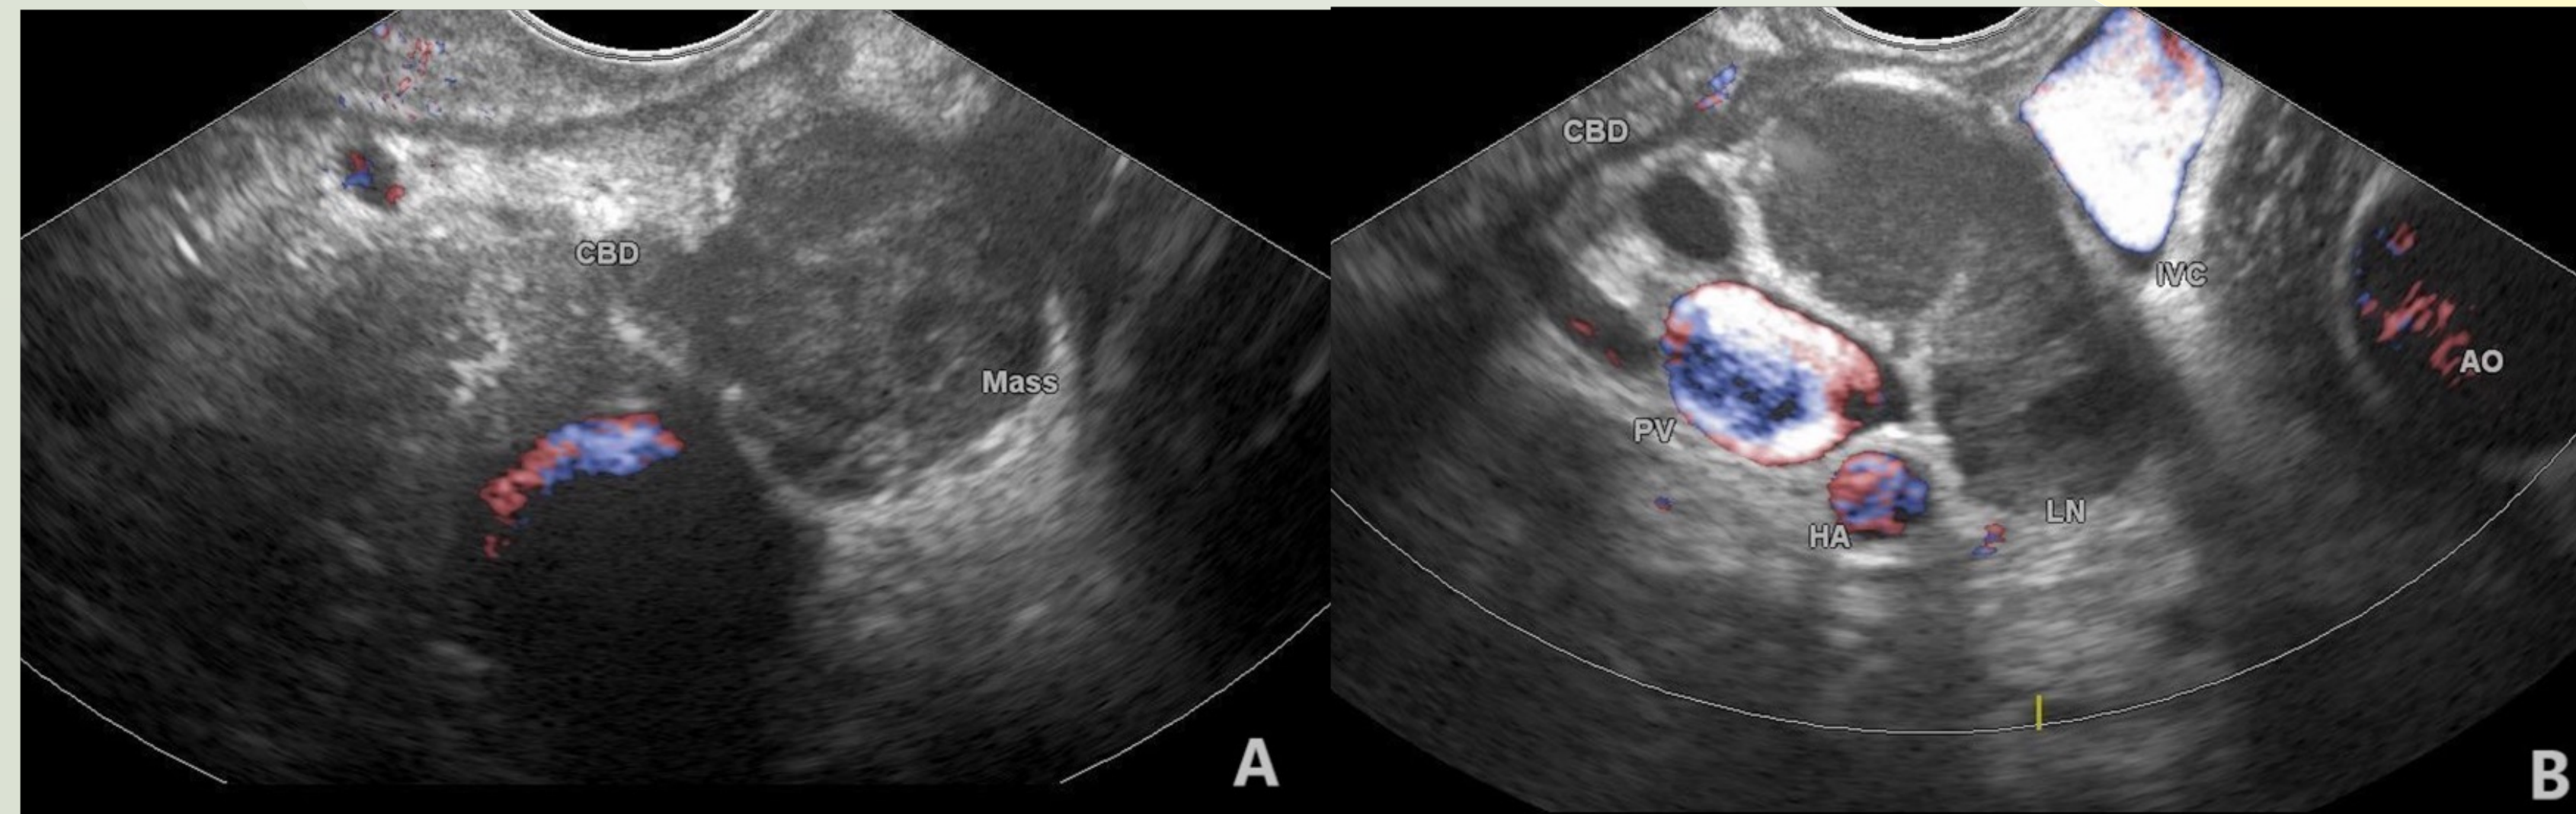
A,B: endoscopic ultrasound images showing the tuberculous lymphadenopathy in close proximity to the common bile duct.
